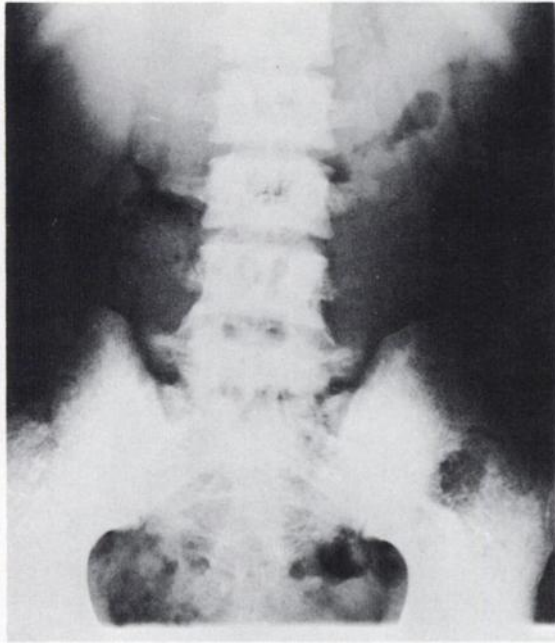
Supine abdomen roentgenogram. Note prominent spleen and liver enlargement and coarsening of trabecular markings throughout the spine and pelvis.
